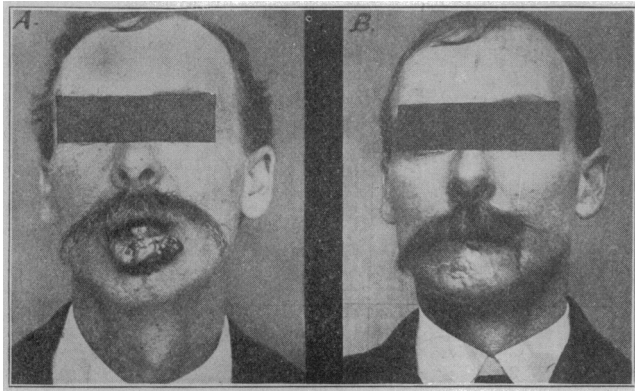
Epithelioma of the lower lip following a fever blister. (A) Began two years before. Had been treated by a plaster unsuccessfully. This was associated with enlarged submental and submaxillary glands. Treated at first for two months by fractional doses of Roentgen rays. It was then excised by Dr. Laplace, and treated the following day by Roentgen rays again. The patient is well today, thirteen years later. (B) Well after a year, and still well, 1916.
